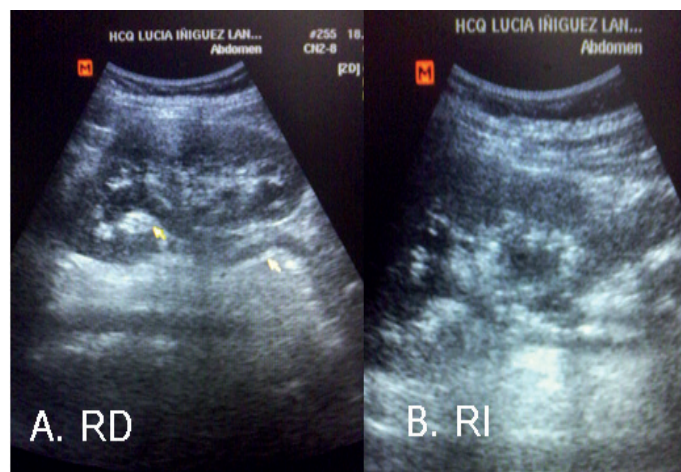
Ultrasound with Valsalva maneuver: bilateral double excretory system associated with double ureter, both dilated
